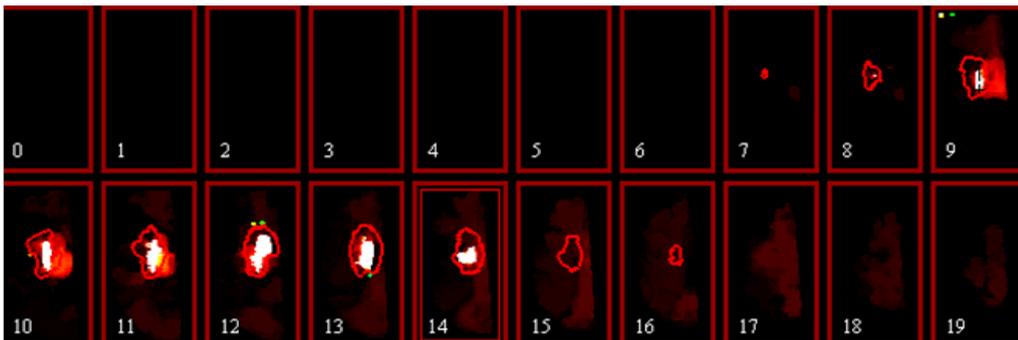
PM* of multi-parameters: *TTP*, *MTT*, *CBF*, *ADC* and *DWI* with reference segmented results at days 30 (Patients171).
